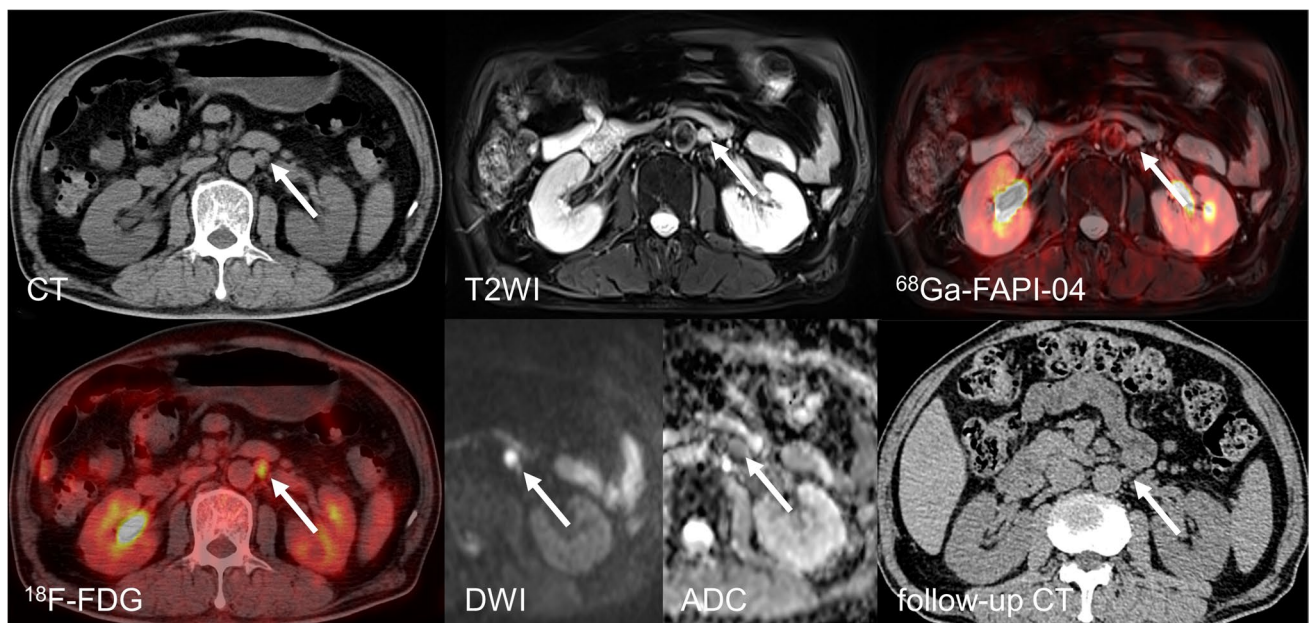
Comparison of ^{18}F -FDG PET/CT and ^{68}Ga -FAPI-04 PET/MR of para-aortic lymph nodes in a 66-year-old man (patient 28). This lymph node measured 1.2 cm in short diameter and showed marked ^{18}F -FDG accumulation ($\text{SUV}_{\text{max}} = 5.6$). On ^{68}Ga -FAPI-04 PET/MR imaging, no increased radioactive uptake was seen in the enlarged node, which made it difficult to determine whether it was benign or
